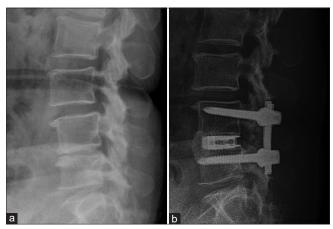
(a) A lateral radiograph of a 42-year-old female showing segmental kyphosis of L4/5 after laminectomy and discectomy. (b) The postoperative radiograph showing good restoration of lumbar lordosis and disc height
